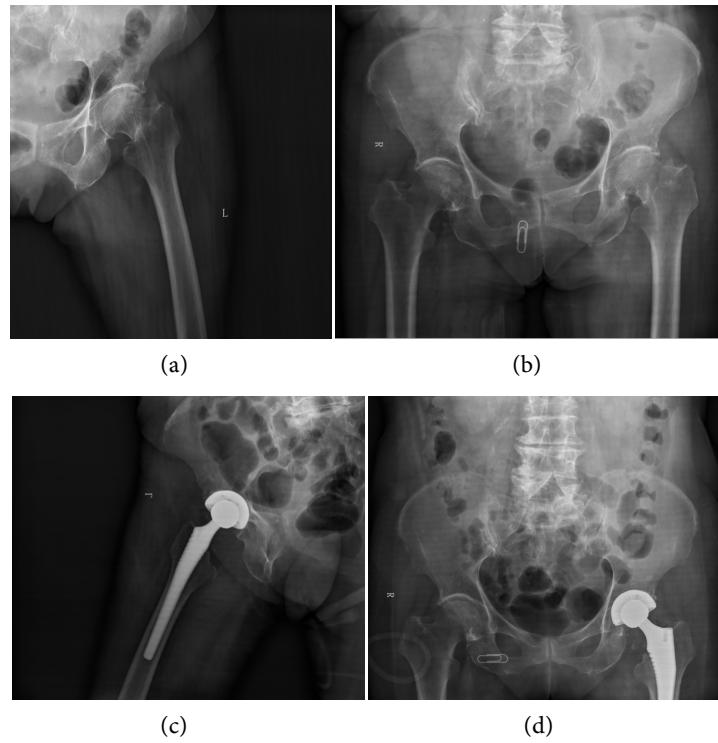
Female, 75 years old, left femoral neck fracture, THA through the DAA. (a) (b) Preoperative pelvis AP and Lateral radiograph of hip joint shows fracture of left femoral neck; (c) (d) Postoperative pelvis AP and Lateral radiograph of hip joint shows that the prosthesis is in good position.
